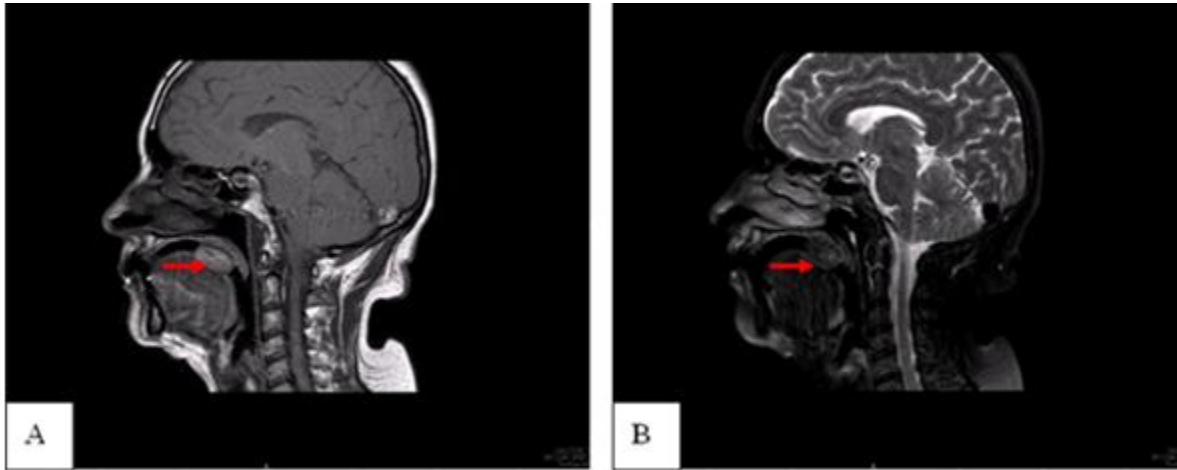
The magnetic resonance imaging exhibited the tumor located over the hard palate presenting hyperintensity on T1-weighted images (A) and isointensity on T2- weighted images (B). The tumor was marked with red arrow.
